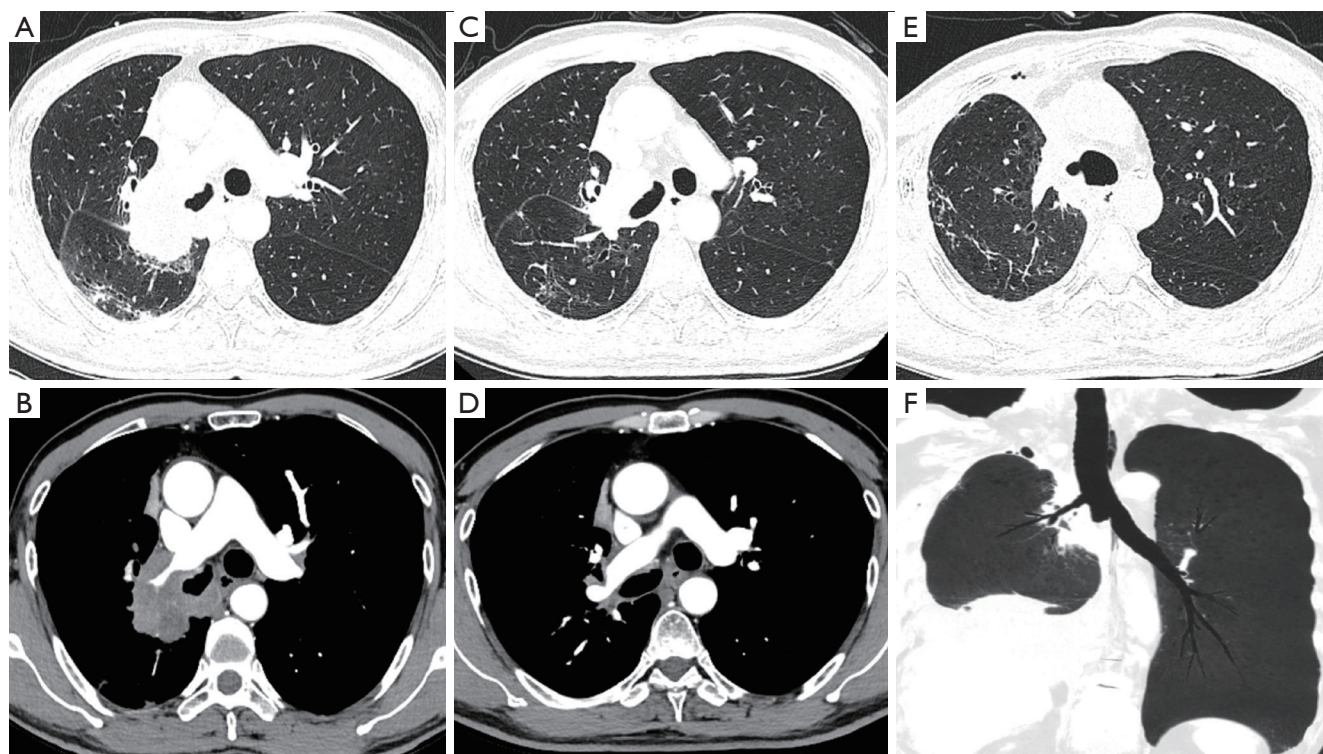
Comparison of the patient before and after neoadjuvant therapy in this study. Before neoadjuvant treatment, CT images revealed a tumor in the right upper lobe, associated with atelectasis, as well as metastasis to bilateral hilar and mediastinal lymph nodes. The tumor also exhibited invasion into the pulmonary arteries and veins (A,B). Following neoadjuvant therapy, subsequent CT scan demonstrated a reduction in the sizes of tumor and hilar and mediastinal lymph node metastases. Additionally, there was an improvement in the invasion of the tumor into the pulmonary vessels (C,D). Postoperative CT scans showed a well-inflated transplanted lung, and the reconstructed airway displayed patent conditions without stenosis (E,F). CT, computed tomography.
